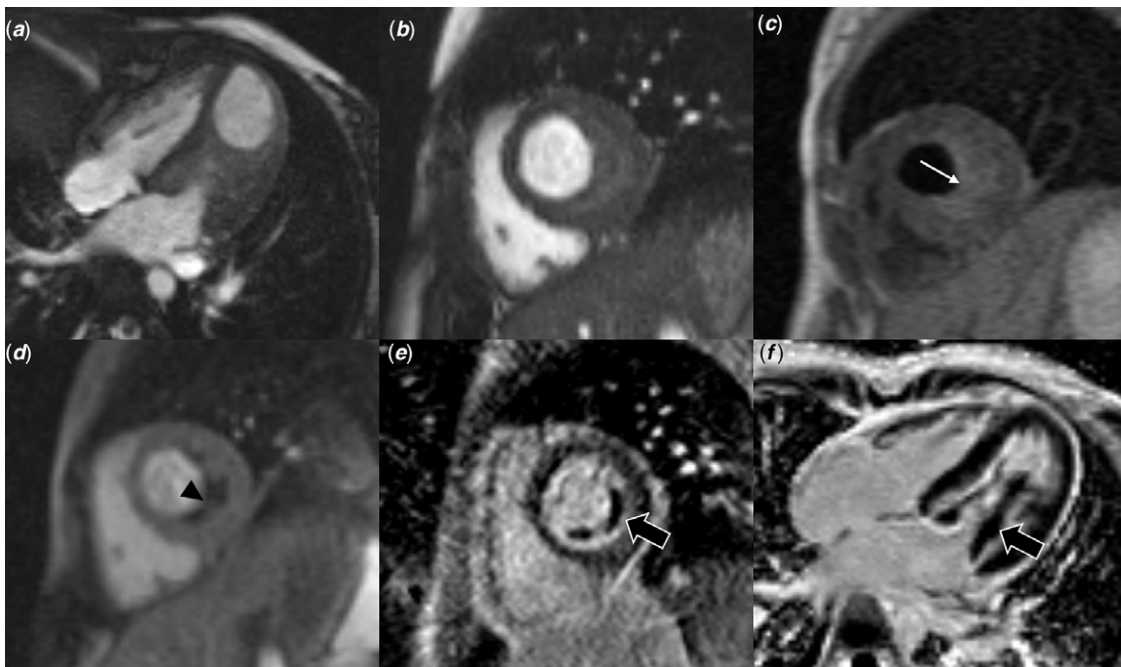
Cardiac MR images demonstrating features of endomyocardial fibrosis and left ventricular (LV) mural thrombus causing systolic obliteration of LV mid-cavity. (a) Cine four chamber and (b) short axis views show eccentric wall thickening and LV mid cavity narrowing. (c) Short axis pre-contrast T1 black blood image shows isointense LV myocardium and mildly hyperintense thrombus along the endocardium (white arrow). (d) Post contrast first pass perfusion shows enhancing myocardium and non-enhancing LV thrombus (black arrowhead). Delayed enhancement short axis (e) and four chamber (f) views show diffuse uniform endocardial enhancement with non-enhancing layered thrombus in the LV cavity (black solid arrow) involving and encasing the papillary muscles.
